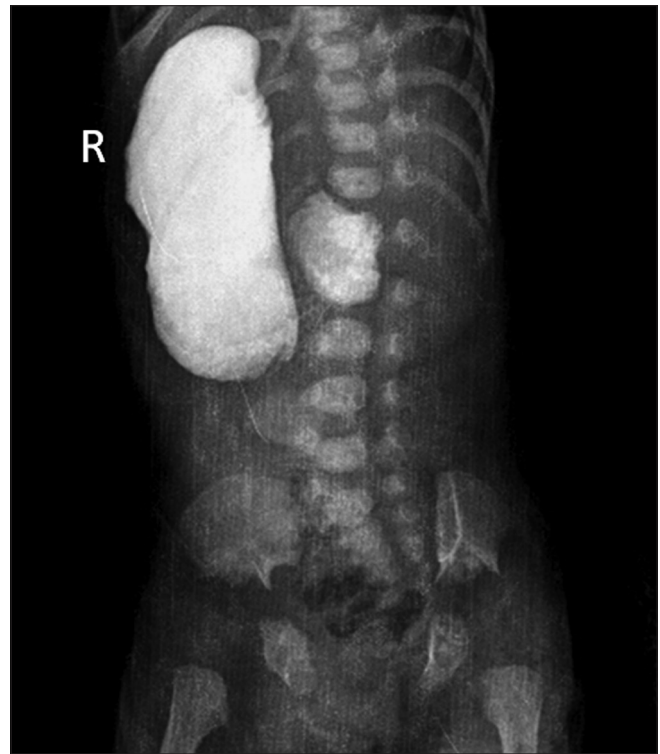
Upper gastrointestinal contrast radiograph obtained at 5 min shows an over-distended stomach located on the right side with a normal pyloric canal
